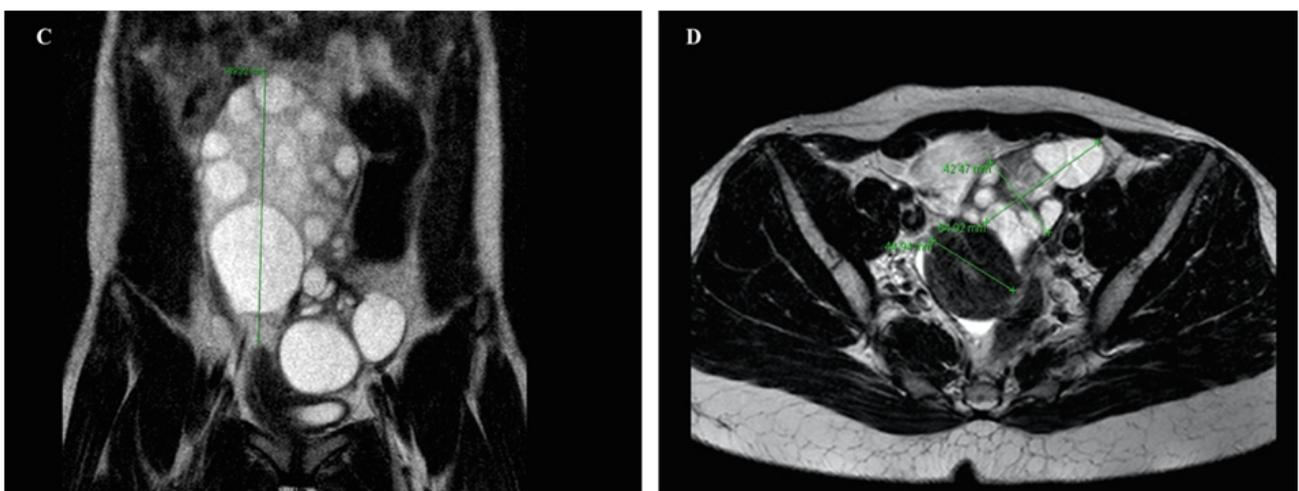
Spontaneous OHSS and FSH-secreting pituitary adenoma. T2-weighted pelvic MRI with (C) sagittal and (D) axial sections showed multicystic enlargement of bilateral ovaries. (left ovary: 65 x 42 x 66 mm, right ovary: 150 x 100 x 60 mm)
